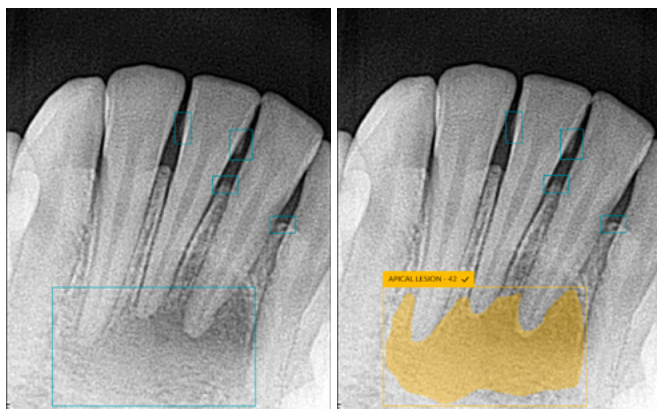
& 2 The images demonstrate that the analysis conducted with AI technology in the DTX Studio Clinic identified an apical lesion that was not clearly visible on the initial X-ray.
